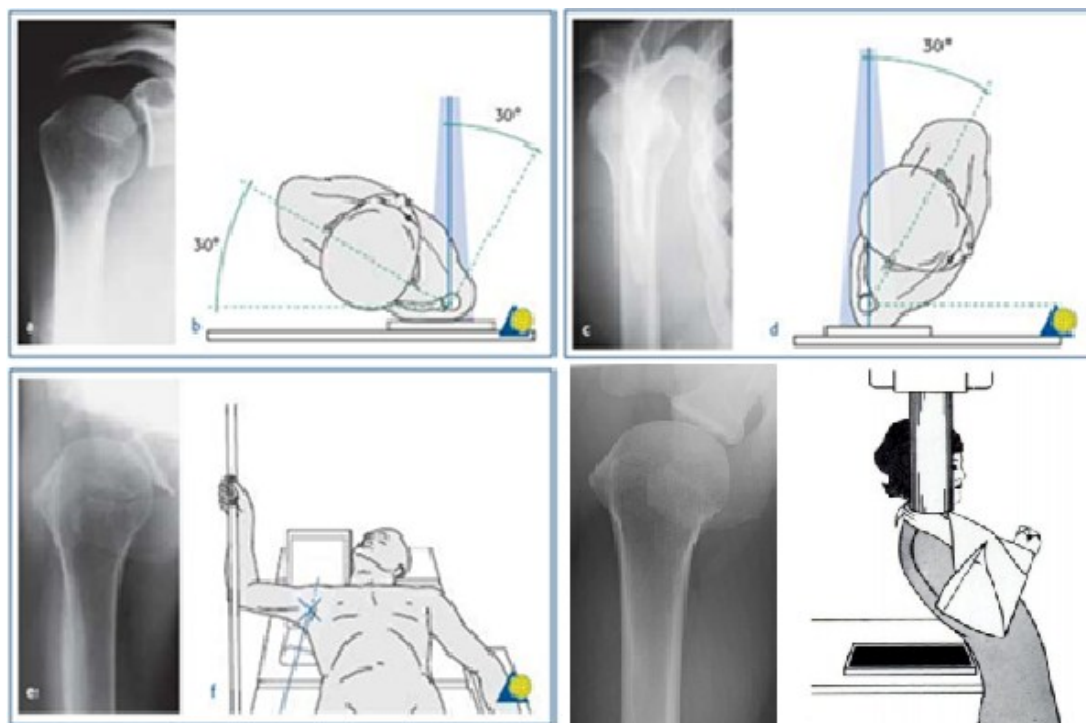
= Common Radiographic Views of the Proximal Humerus:
